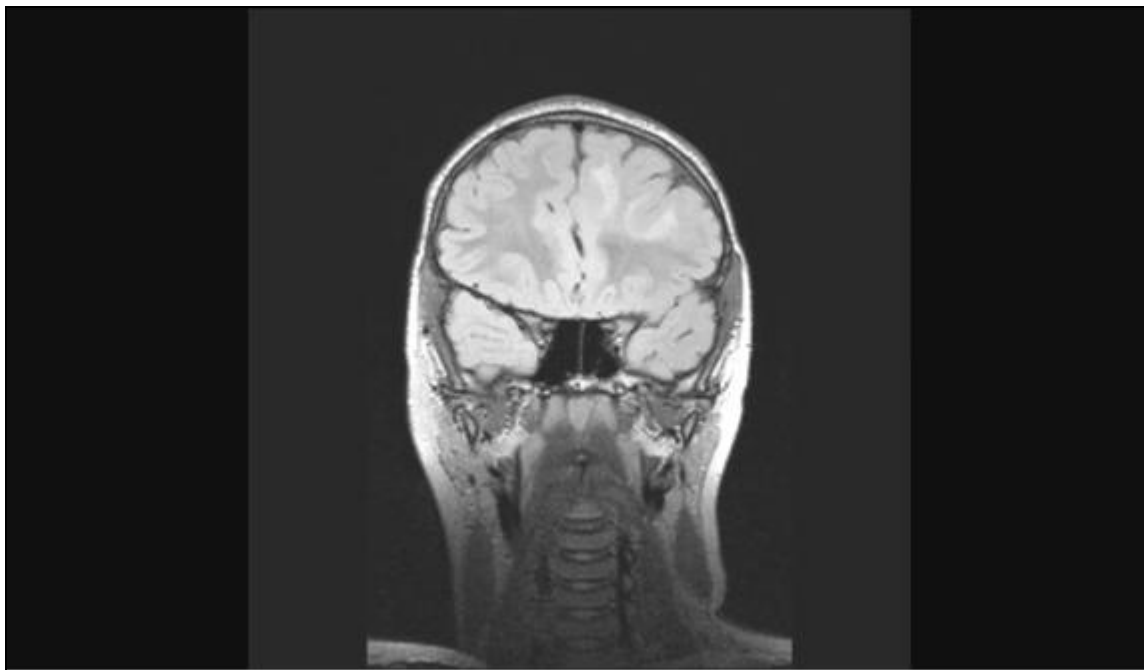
3T-MRI of the brain with left frontal cortical dysplasia.
